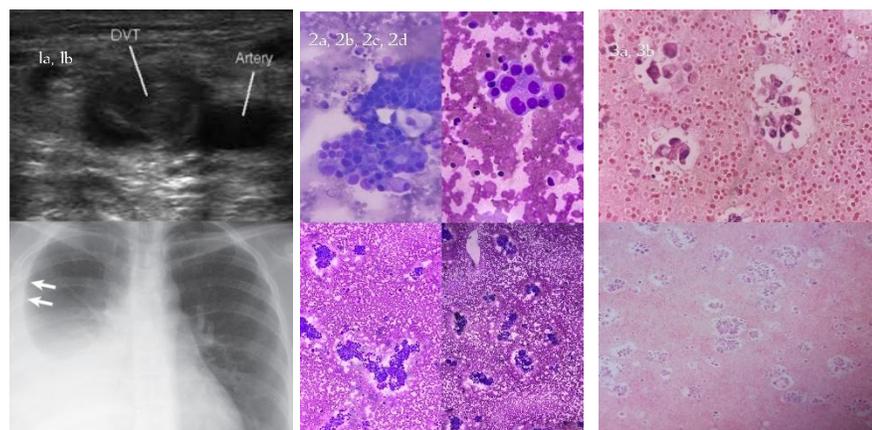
Leg Doppler and Chest X-Ray
